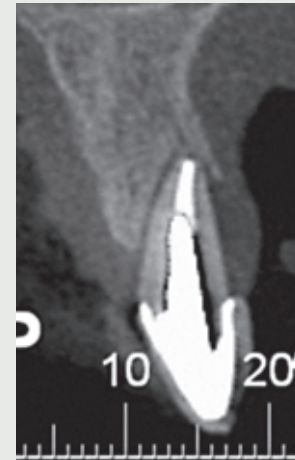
Total loss of buccal bone wall as observed by cone beam computerized tomography.
